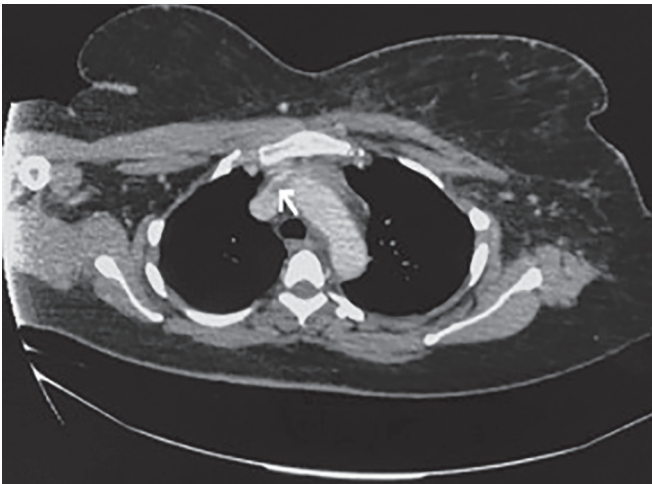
A CT venogram showing minimal extension of thrombosis to the superior vena cava and internal jugular vein
